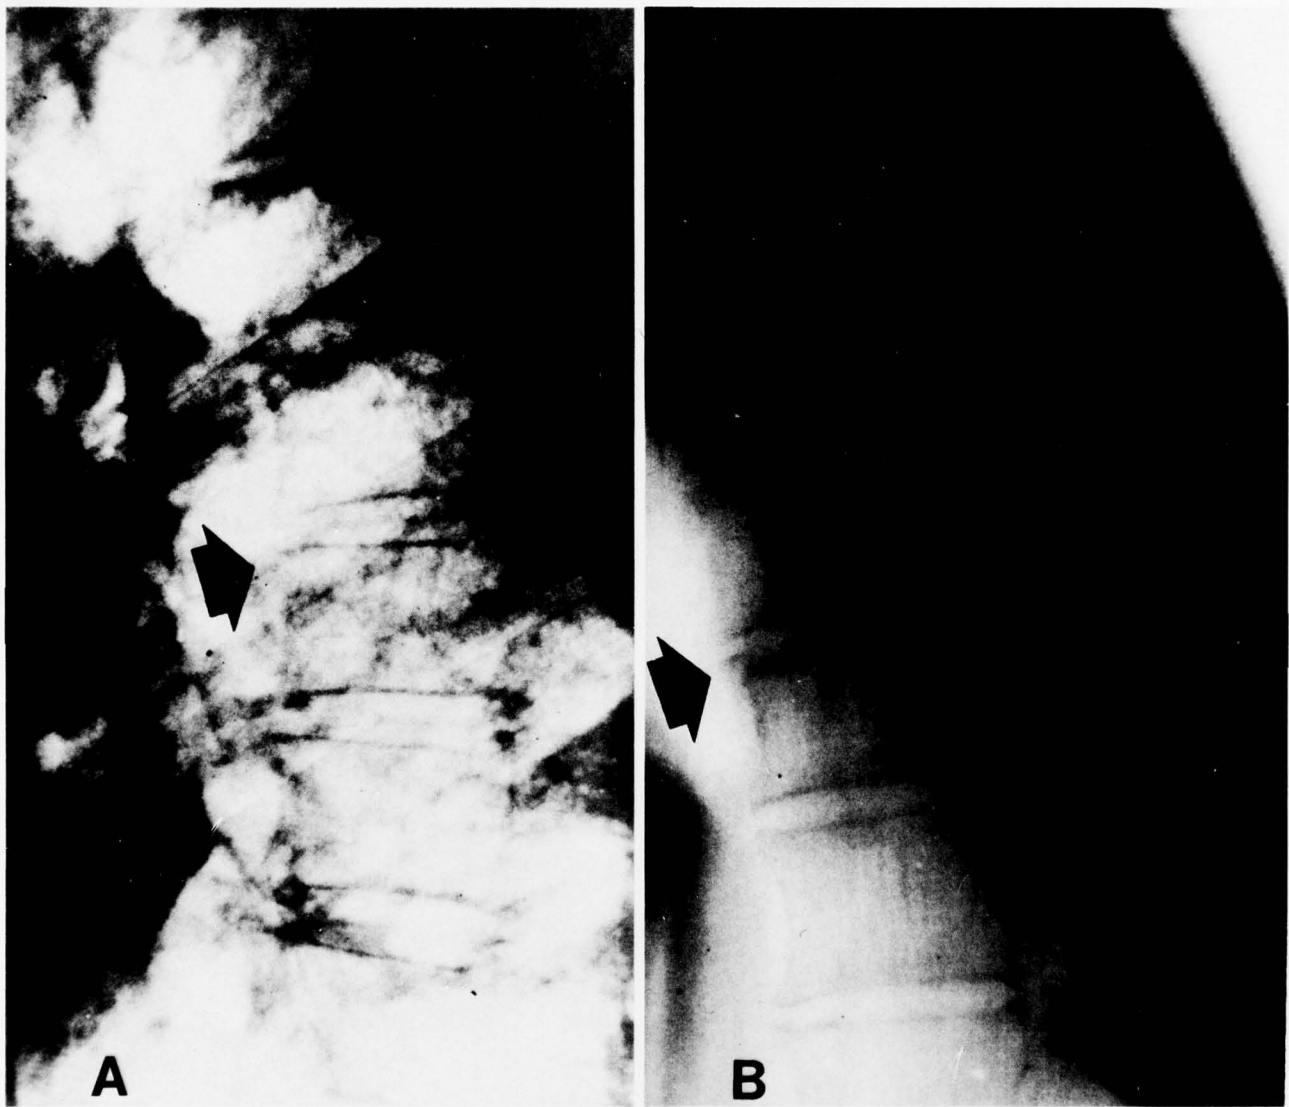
Example of a Routine Radiograph (A) Versus Tomographic View (B)
